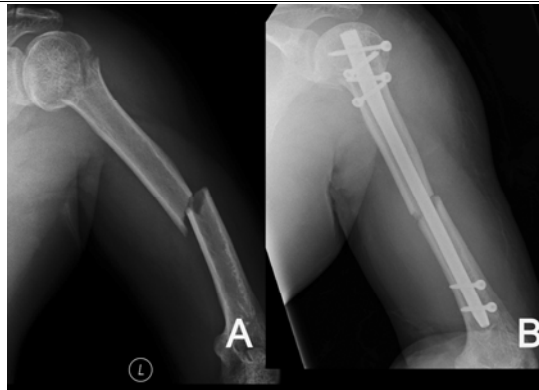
A 40-year-old man (case No. 5) sustained fracture after road traffic accident: A) Plain radiographs showed ipsilateral humeral neck and shaft fractures; B) The patient was treated with antegrade intramedullary nail Polaris (Acumed, Beaverton, OR) and postoperative radiographs presented 3 mm gap between the fracture fragments. The patient developed shaft nonunion which required autogenous bone graft.
